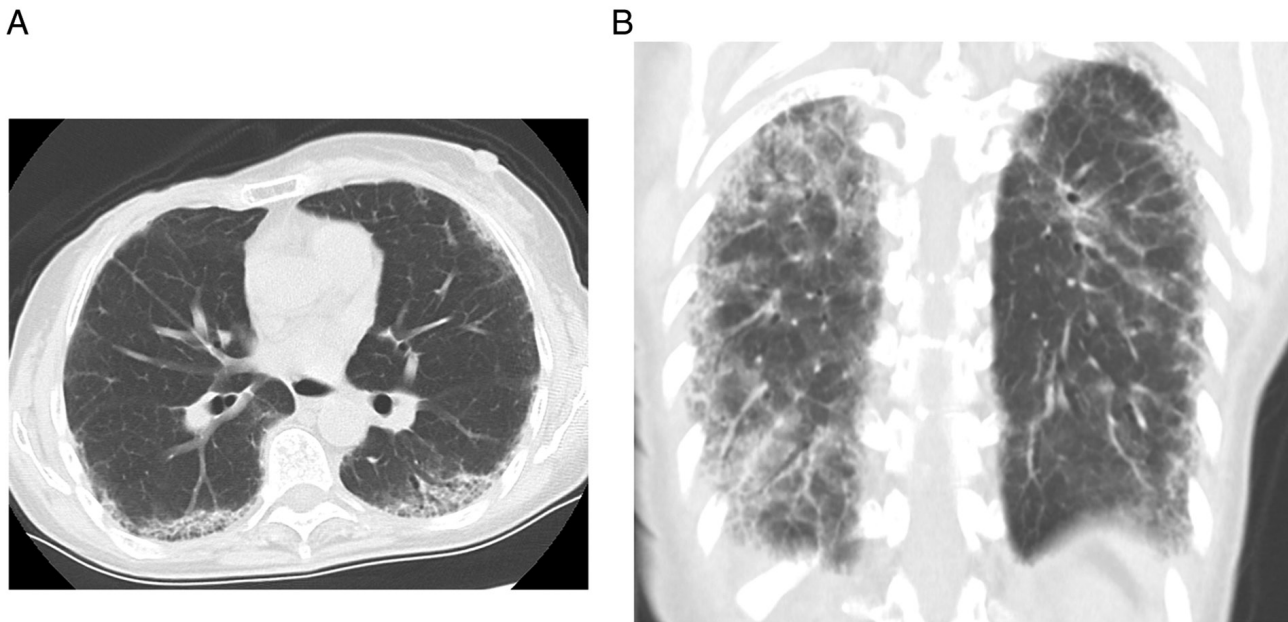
Chest computed tomography reveals ground-glass opacities and linear shadows in the peripheral lower lobes of both lungs. (A) Axial section view, (B) coronal section view.
